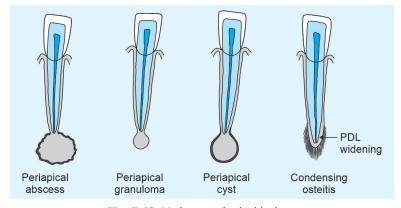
Various periapical lesions
